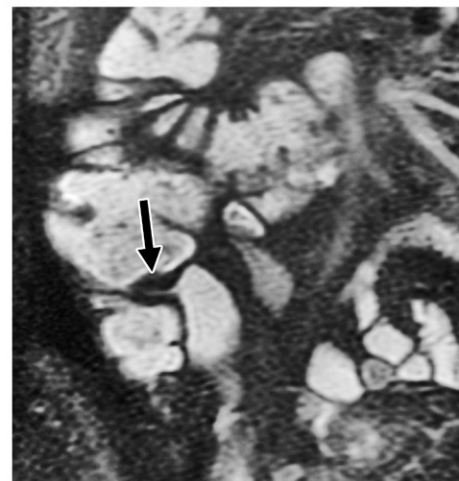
Crohn disease with no imaging signs of active inflammation. (a, b) Coronal contrast-enhanced fat-suppressed T1-weighted (a) and fat-suppressed T2-weighted (b) MR enterographic images with biphasic oral contrast material in a patient with Crohn disease show active inflammation in the terminal ileum (arrow) at the ileocecal valve, with bowel wall thickening, mural edema, and stratified mural hyperenhancement. (c, d) Posttreatment coronal contrast-enhanced fat-suppressed T1-weighted (c) and fat-suppressed T2-weighted (d) MR enterographic images with biphasic oral contrast material show minimal residual wall thickening (arrow), with resolution of the mural edema and hyperenhancement, consistent with Crohn disease with no imaging signs of active inflammation.
